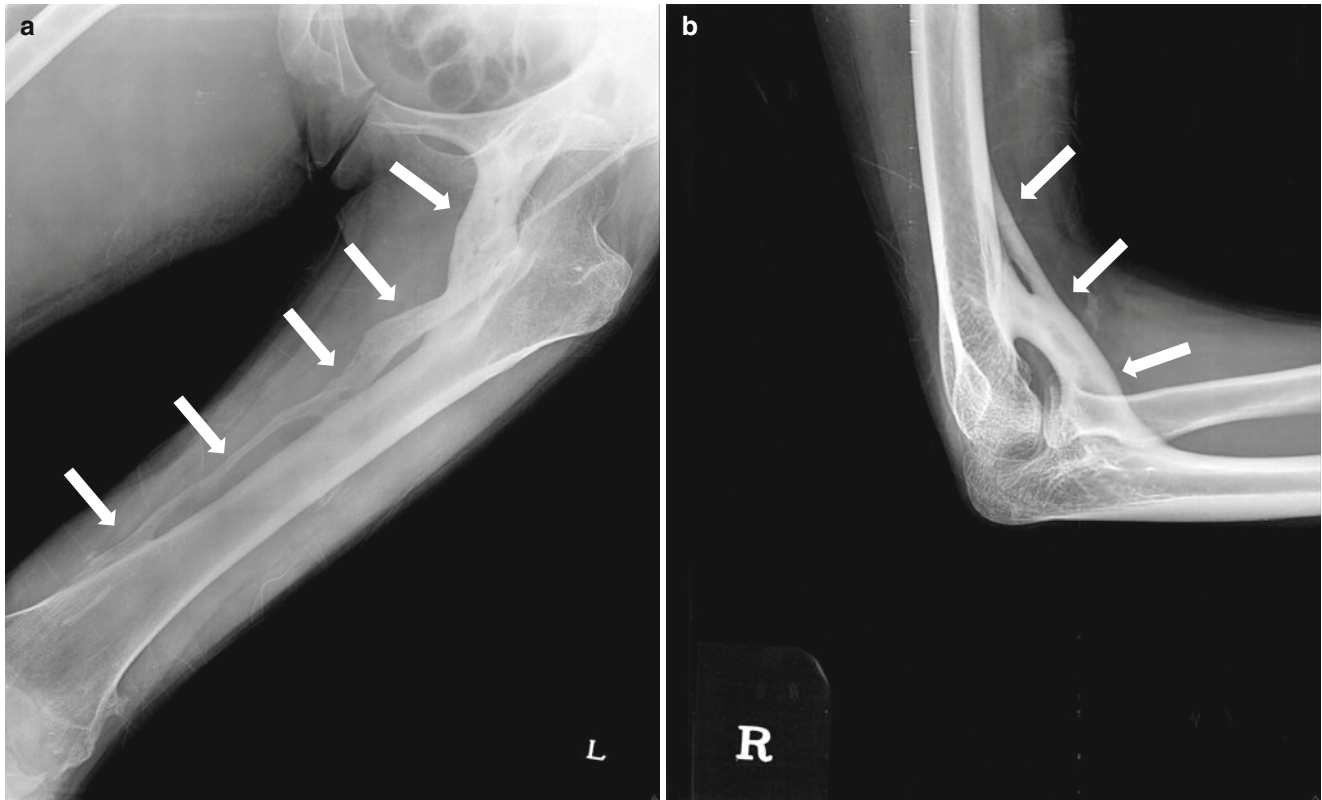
Radiographs and MR images of an 18-year-old girl who sustained myositis ossificans progressiva. She presented with edema of the right leg. (a) A radiograph of the left femur shows dense bridging ossification (*arrows*) in medial aspect of thigh. (b) Lateral radiograph of the elbow shows bony bridge (*arrows*) between the ventral aspect of humerus and ulna. (c) An anteroposterior (AP) radiograph of a foot shows dense soft tissue ossification resulting in the appearance of exostoses from the metatarsal bone of great toe with mild hallux valgus (*arrows*). Ankylosis of interphalangeal joint of great toe is also observed
